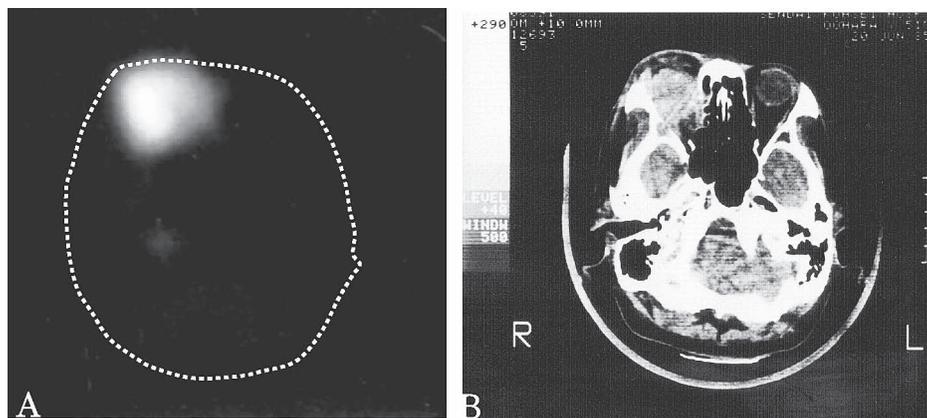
PET images of an orbital metastasis from hepatocellular carcinoma with  $^{18}\text{F}$ -FDGal and  $^{18}\text{F}$ -FDG.
